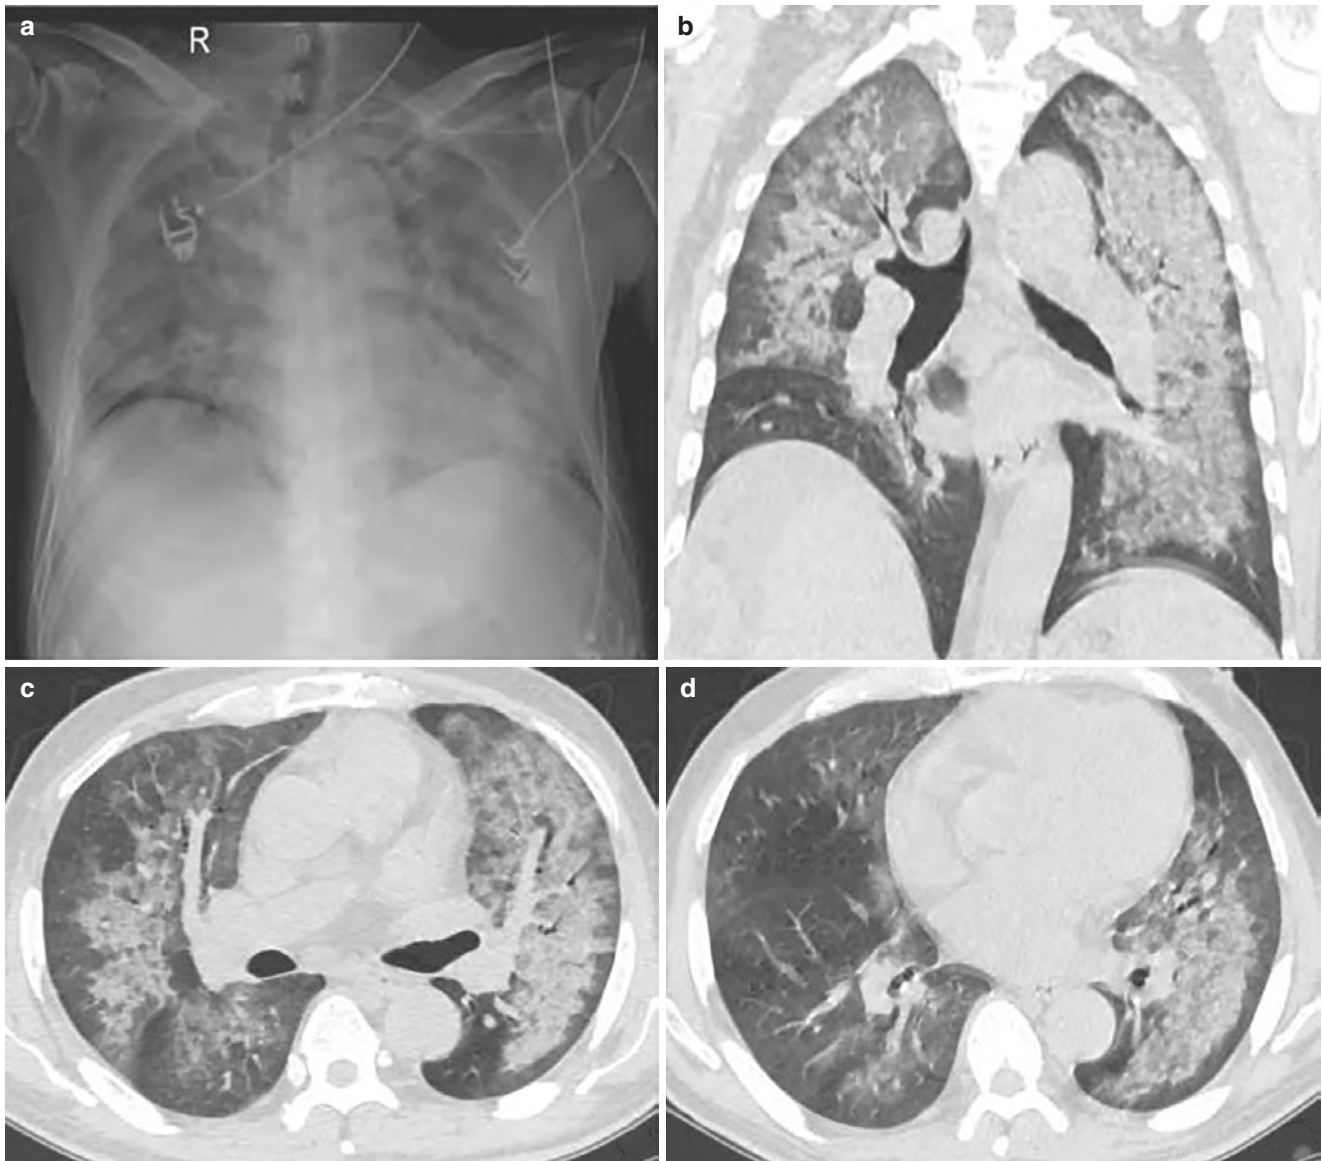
Diffuse alveolar damage caused by bleomycin. (a–d) CT showed diffuse patchy ground-glass opacities in both lungs and thickened interlobular septa, manifested as “paving stone” sign
